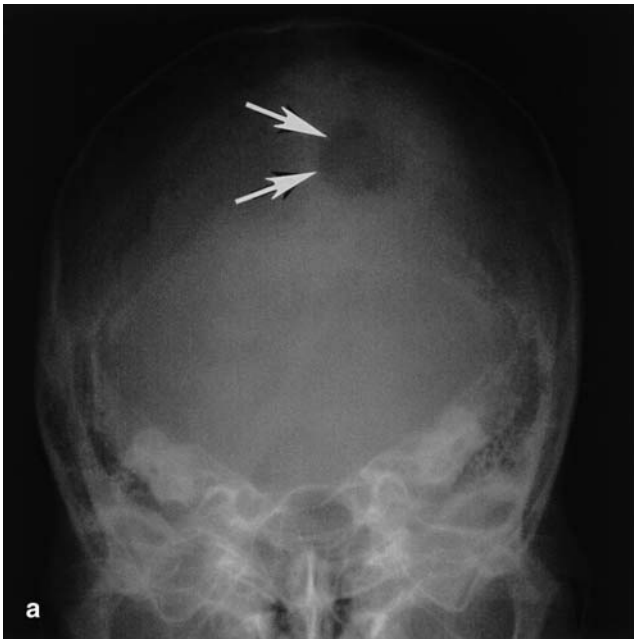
Skull and mandible metastases. a Town's view shows an osteolytic lesion in the left parietal bone (*arrows*). b The CT scan shows a rim-enhancing mass with bony destruction in the mandibular body (*asterisk*)
